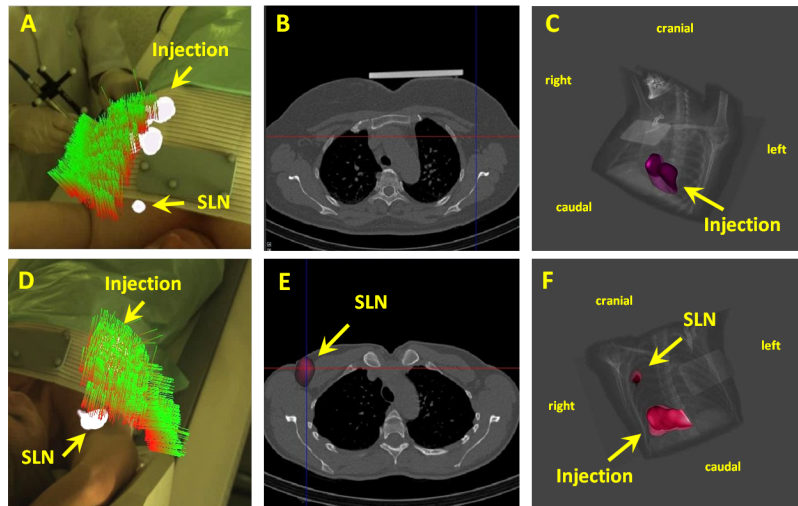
Examples of a poor quality (A-C) and one good quality scan (D-F). The lines shown in A and D represent the positions and orientations of the gamma probe during the scan. In A and D, the injection site and the SLNs as seen in the SPECT image are also shown, co-registered in the correct position. In B and E, the freehand SPECT images are co-registered with CT data derived from SPECT/CT data. In C and F, co-registered visualization is rendered from an arbitrary point of view. One SLN can be seen in 3D fused visualization for the good scan (F) together with the injection site. In the poor quality scan, only the injection site is visible (C). The poor scan clearly misses the SLN (A), while several readings cover the SLN in the case of the good scan (D).
